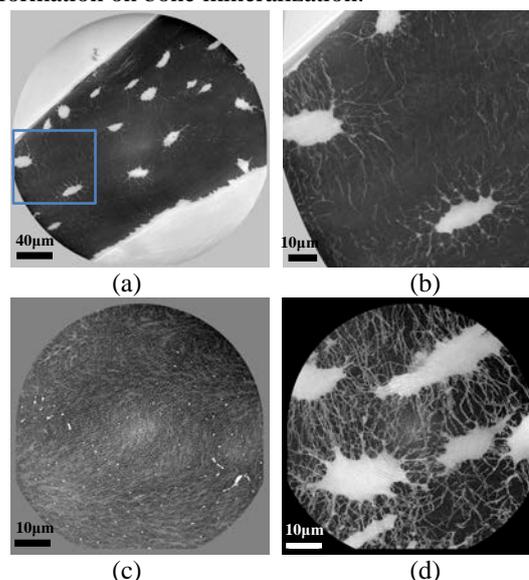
cortical bone images obtained with X-ray phase nano-CT at 120 nm (top line) and 30 nm (bottom line). (a)-(c): selected slices (b)-(d) MIP images
